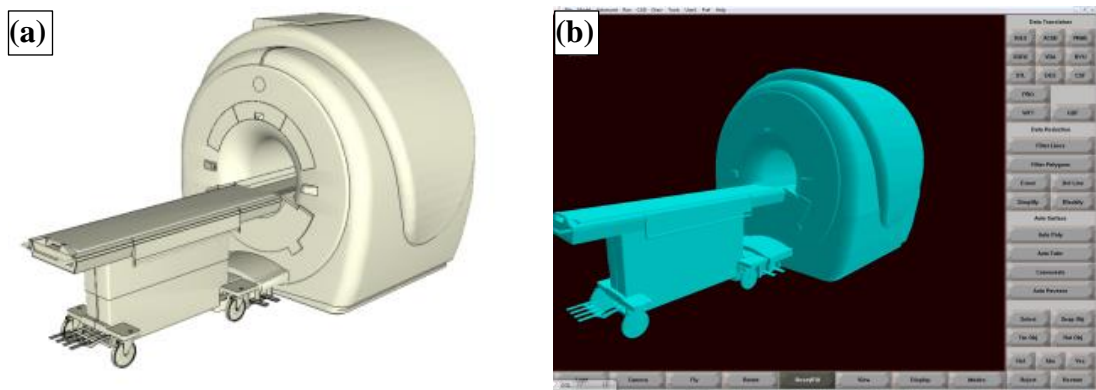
(a) 3D model of an MRI scanner with table in Sketchup v7, (b) 3D model converted into STL format and incorporated into Delmia Quest through the CAD world.
